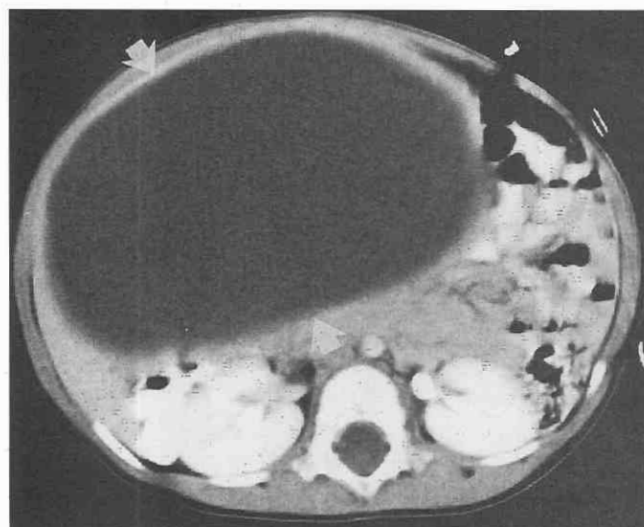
Mesenchymal hamartoma. Contrast-enhanced CT image of the liver demonstrates a large low-attenuation lesion (arrows).
